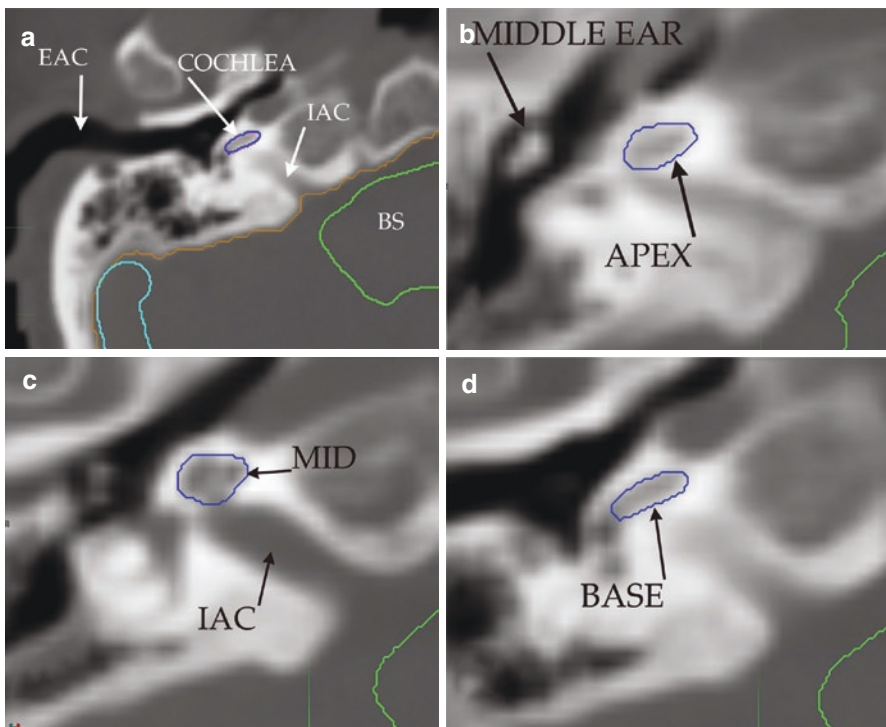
Temporal bone and cochlea. Panel (a) shows the overview of the temporal bone in a bone-window axial CT image. The external auditory canal (EAC) is on the left of the image and the internal auditory canal (IAC) is on the right, adjacent to the brainstem (BS). This section is at the level of the basal turn of the cochlea as is panel (d). Panel (b) is the most superior of the three following levels and is at a level that cuts through the apical turn of the cochlea. The middle ear is seen to the left with the superior portions of the malleus and incus present. Panel (c) cuts through the middle of the IAC, and the mid-modiolar section of the cochlea is contoured. The lowest level, panel (d), cuts through the basal turn of the cochlea
